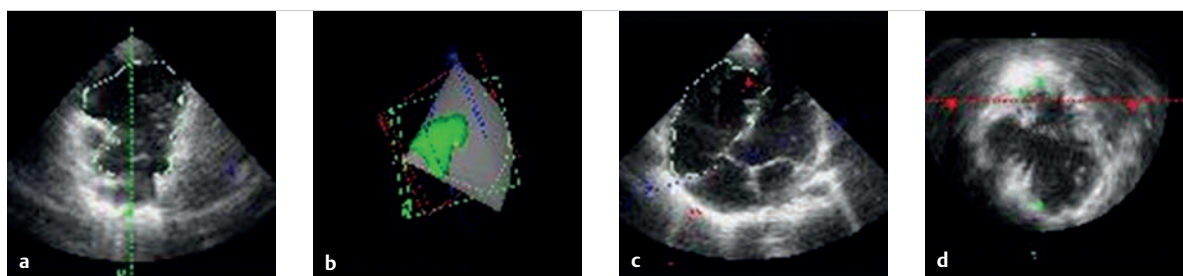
3-D echocardiography. 3-D volume reconstruction of the right ventricle in a patient with surgically treated tetralogy of Fallot and a significantly enlarged right ventricle.
